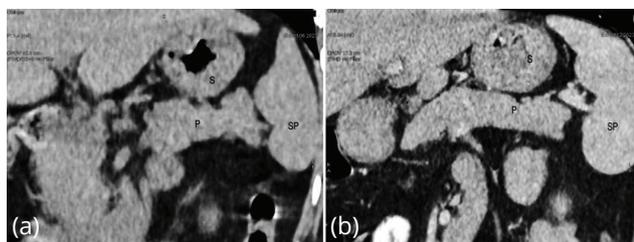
Abdominal computed tomography imaging showing the level of location of the pancreatic tail is at the level of the splenic hilum (a) and inferior to the level of the splenic hilum (b). S- stomach, P- pancreas, SP- spleen.
